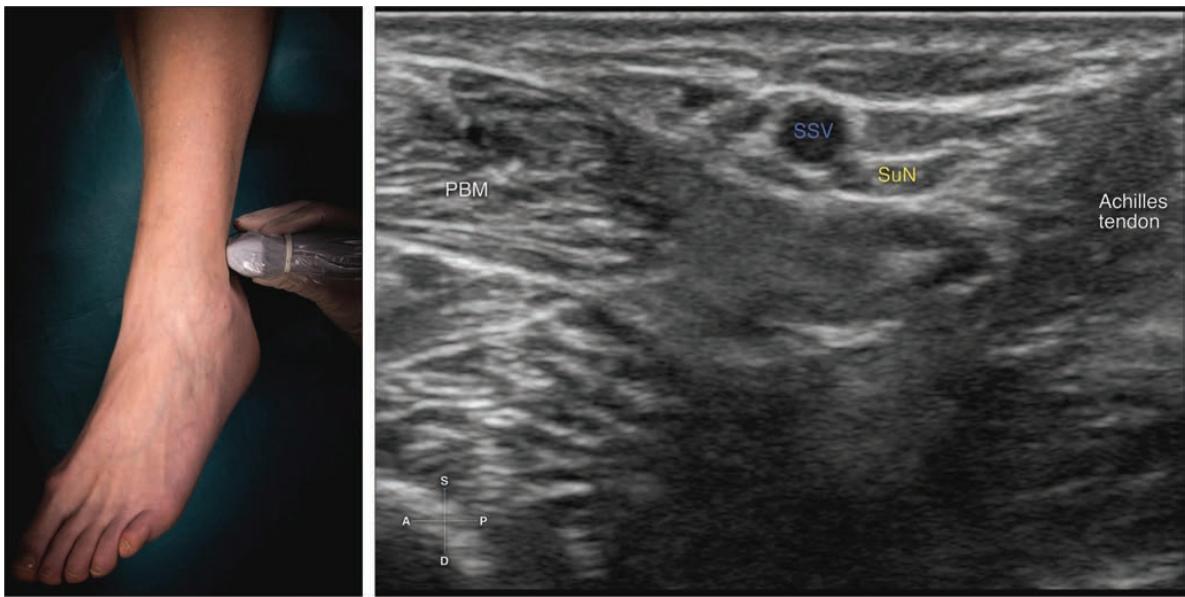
Transducer position and ultrasound anatomy to block the sural nerve. PBM, peroneus brevis muscle; SuN, sural nerve; SSV, small saphenous vein.
